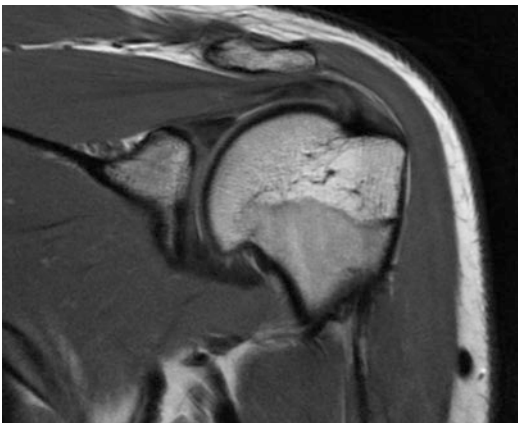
MRI scan demonstrated increased signal intensity in the supraspinatus tendon consistent with tendinosis
